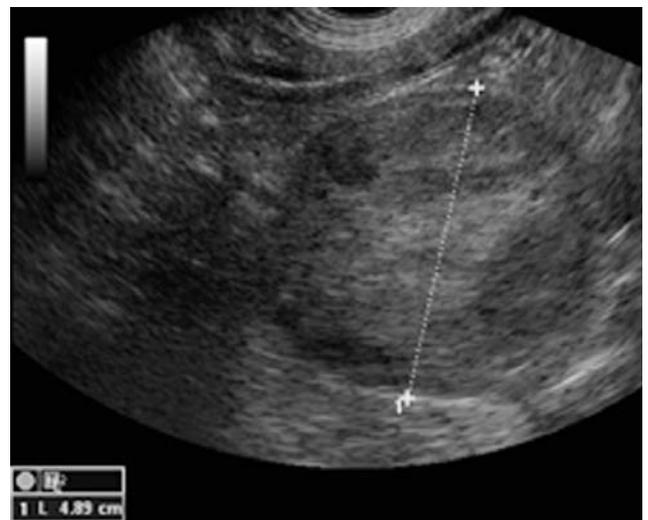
Longitudinal ultrasound image of an adrenal carcinoma. Note the severe enlargement, rounding and heterogeneity of the gland.
